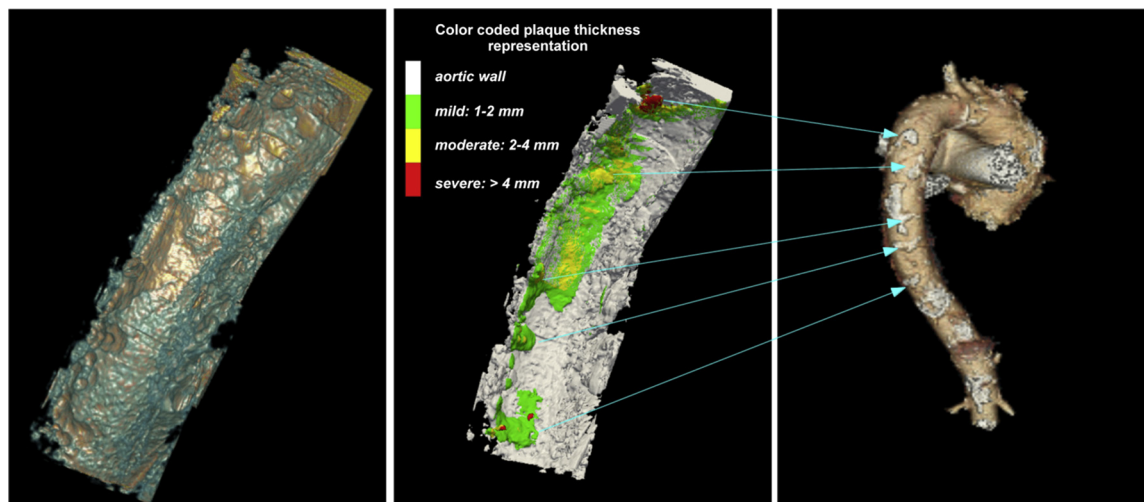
Left: Volume rendering of the 3-D transesophageal echocardiographic fused image. Center: Surface rendering after segmentation of the fused image with color-coded plaque thickness. Right: Volume rendering of the reconstructed aorta from computed tomography. Plaque correspondence between 3-D compounded echo and computed tomography is highlighted by blue arrows.
